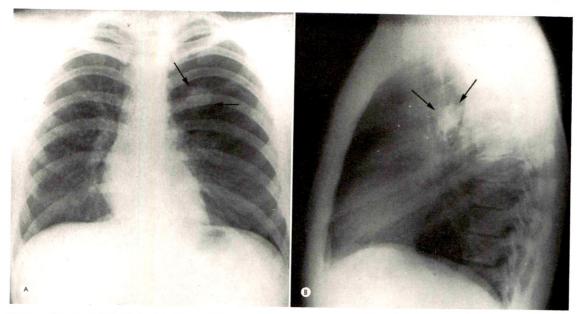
Case I. (A) Posteroanterior and (B) lateral roentgenograms of the chest of a 17 year old male demonstrating the presence of a mass-like lesion in the left upper lobe (arrows) and obvious emphysema in a portion of the left upper lobe.
